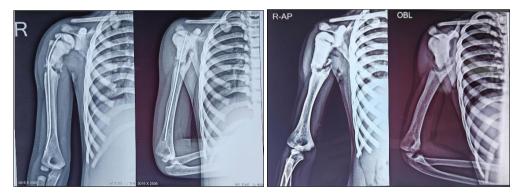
Old xrays- before and after TENS removal
